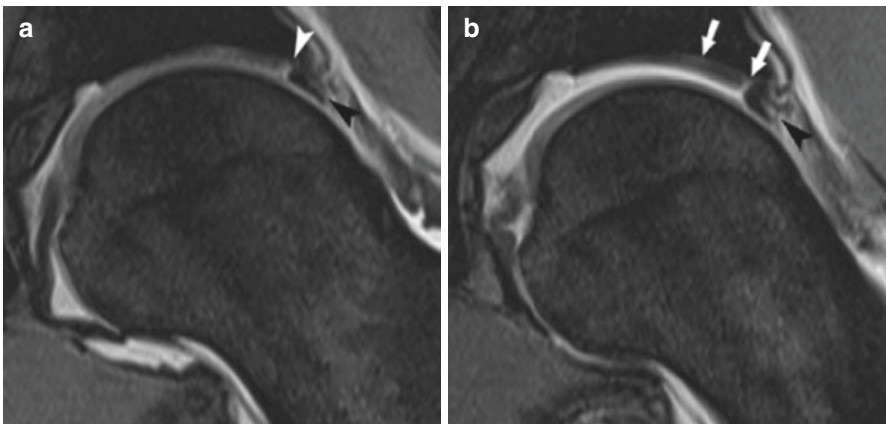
43-year-old man with cam-type FAI. (a) Black and white arrowheads indicate complex labral tear in coronal T1-weighted MR arthrogram (MRA) image. (b) Articular cartilage layers became more distinguishable with traction. White arrows indicate the delamination tear of the acetabular cartilage, and black arrowhead indicates dislocation of intrasubstance labrum component of the complex labral tear. (Reprinted by the permission of Springer Berlin Heidelberg, Diagnostic performance of direct traction MR arthrography of the hip: detection of chondral and labral lesions with arthroscopic comparison. Schmaranzer F, Klauser A, Kogler M, Henninger B, Forstner T, Reichkender M, Schmaranzer E. *Eur Radiol.* 2015 Jun;25(6):1721–30. <https://doi.org/10.1007/s00330-014-3534-x>)
